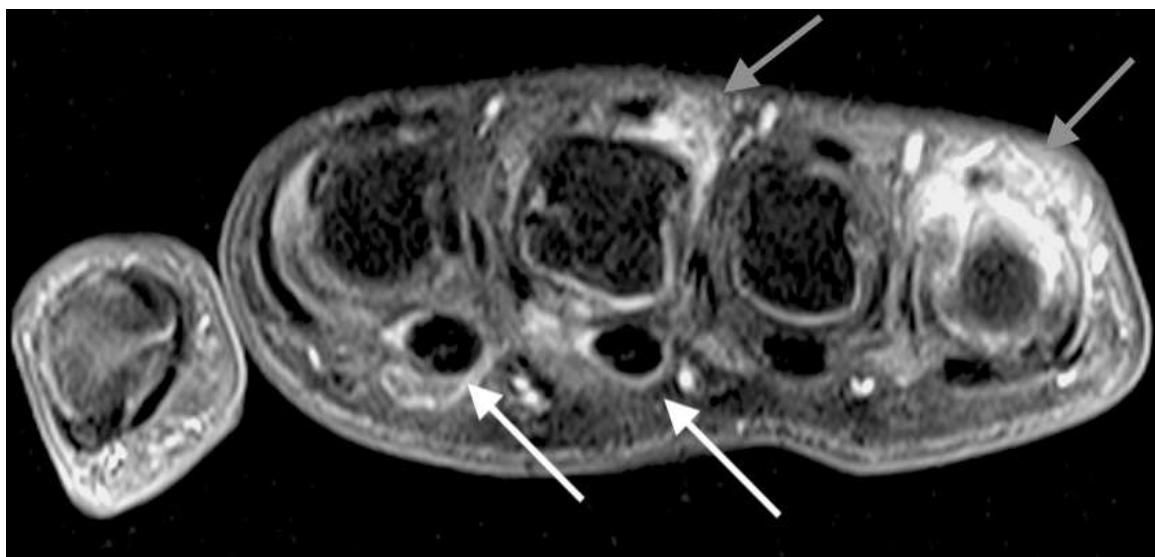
MRI T1 pre-contrast with fat saturation in the axial plane of right hand. Note the metacarpophalangeal synovitis and flexor tenosynovitis of the second and third digits (arrows).
